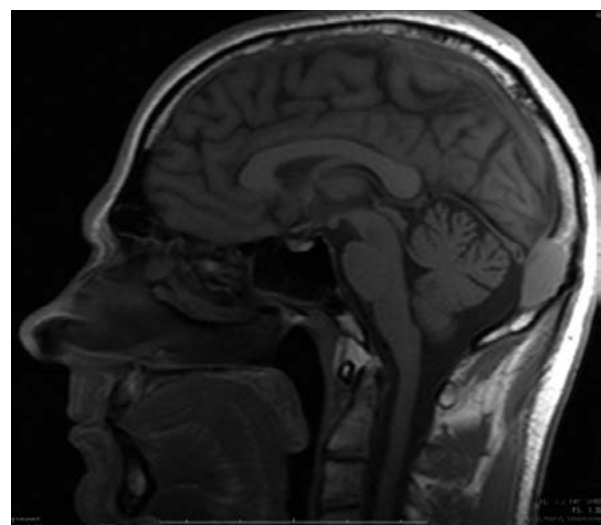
Preoperative MRI, sagittal view
